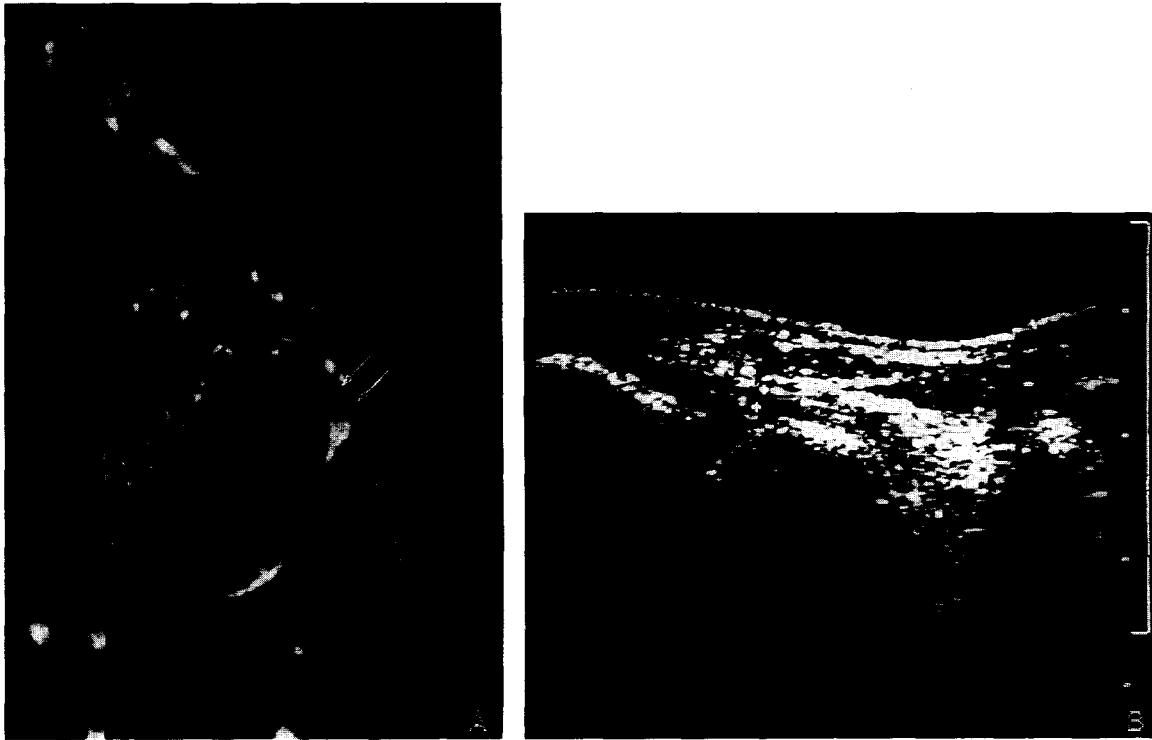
Anterior Talofibular Ligament: (A) T2WI oblique axial MR image shows anterior talofibular ligament(arrows), form the lateral maleolus to the talar neck and body junction. (B) Ultrasonography obtained with direction parallel to the anterior talofibular ligament, also demonstrates the intact anterior talofibular ligament as a echo poor linear band.(arrows).
